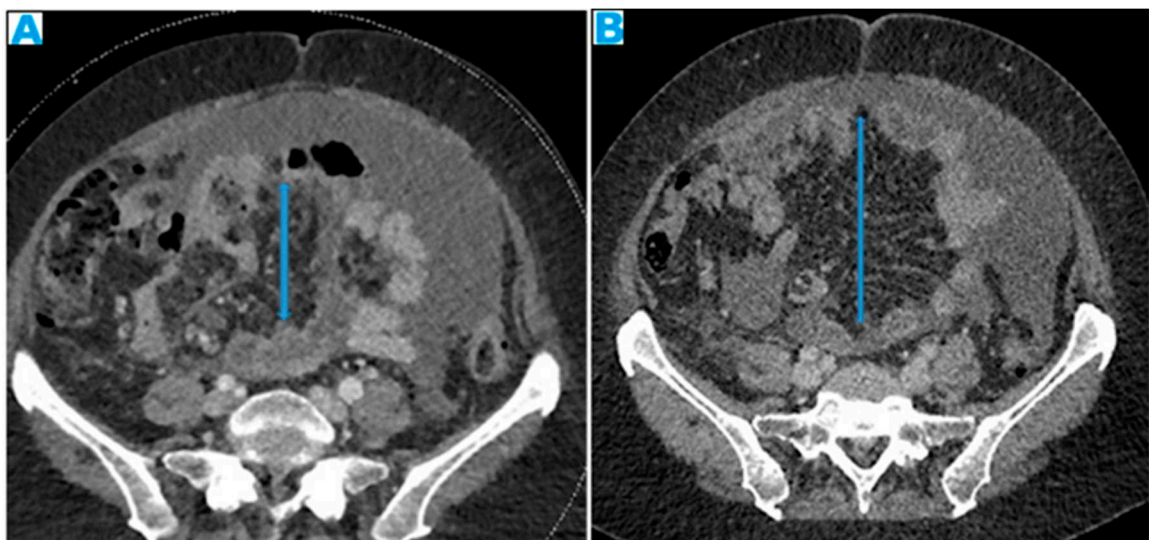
Axial CE-CT, current study (A) and from six months prior (B). PC from colon carcinoma: The mesentery becomes fibrotic as the seeding evolves and, secondary to the retraction effect, a decrease in size of the mesenteric fat will occur (arrows). This effect may be more conspicuous than the actual deposits.
